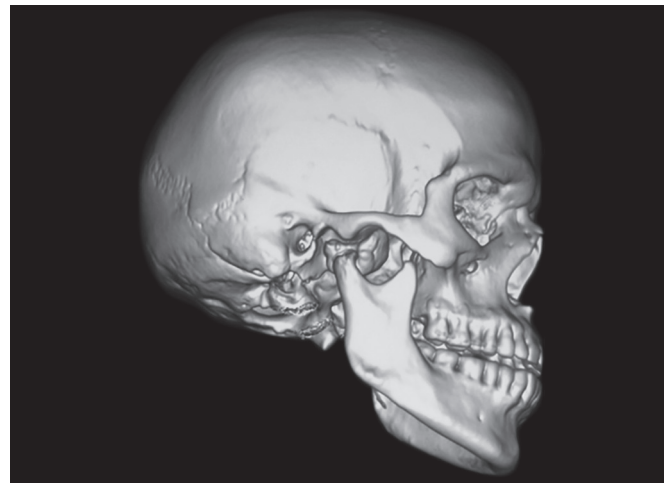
Three-dimensional CT showing lesion on the medial aspect of right condylar head
